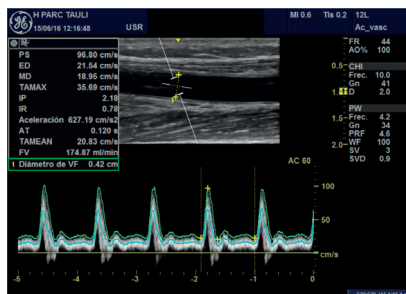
Doppler Mode. High Resistivity Index (0.78).
